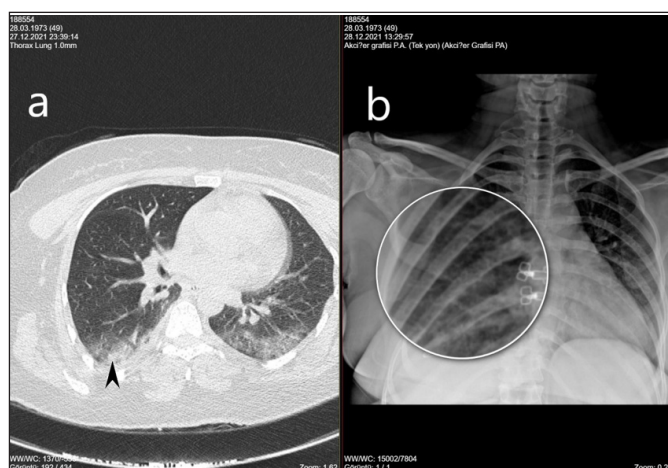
In the CT sections passing through the inferior pulmonary vein level in the axial sections, the consolidation area with an anteroposterior thickness of 2 cm (cutted arrowhead) accompanied by GGO 1b. This consolidation is not seen in the magnified CRX image taken from the same area
